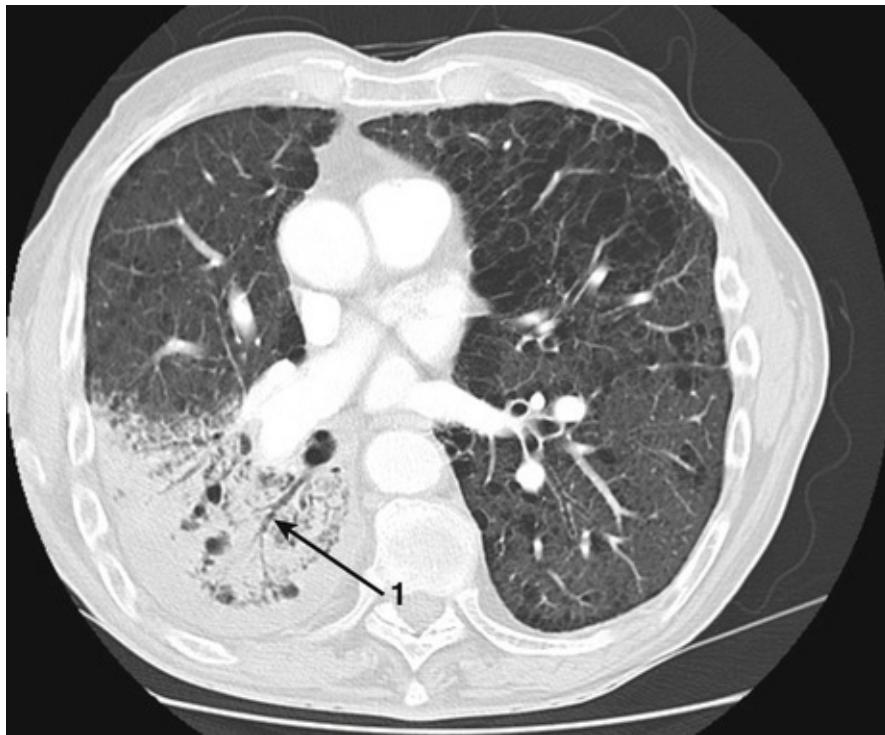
CT lung window settings. This is the CT of 69-year-old man with history of COPD, who was admitted severely unwell with history of increased breathlessness, cough and fever. The CT shows an area of dense consolidation in the right lower lobe. The black airways (1) against the white background of fluid-filled airspaces indicate consolidation.
